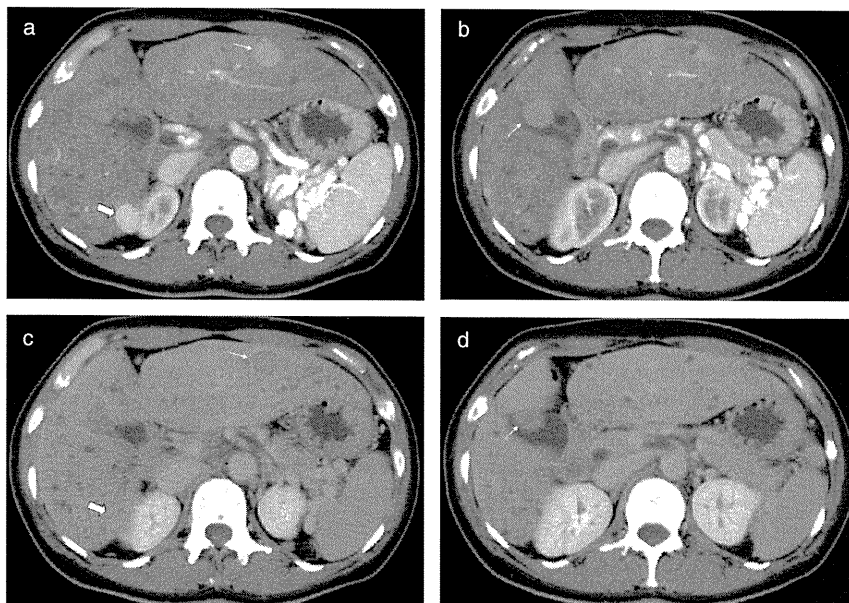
The nodules at S3 (arrow) (a), S5 (arrow) (b), and S6 (large arrow) (a) were enhanced on computed tomography at the early arterial phase. Hypoattenuation at the portal phase was only observed for the nodules at S3 (arrow) (c) and S5 (arrow) (d). The nodule at S6 displayed isodensity at the portal phase (large arrow) (c).
